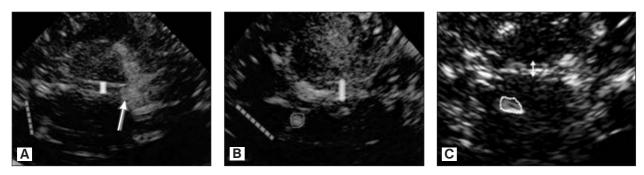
Sonographic images at the level of thalami (ventricular system). (A) Normal finding at the thalamic level, BG and thalami are invisible i.e. isoechogenic with surrounding cerebral white matter; normal diameters of the third ventricle (full line) and the frontal horn of the lateral ventricle (dotted line); full thick arrow depicts hyperechogenic pineal gland. (B); Hyperechogenicity of the CN (encircled with dotted line), located next to the frontal horn of the lateral ventricle (depicted with the dotted line, normal diameter); (C) Hyperechogenicity of the LN (encircled with dotted line) located close to the third ventricle (depicted with arrow, normal diameter).
